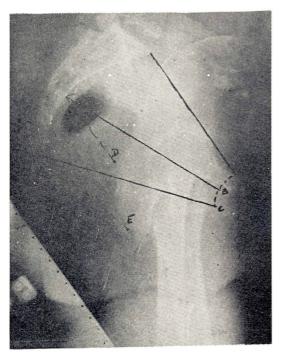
X-ray pelvimetry — lateral projection, showing various antero-posterior diameters. A = inlet true conjugate. B = antero-posterior diameter of mid-pelvis. C = antero-posterior of outlet. D = post-sagittal diameter of mid-pelvis. E = post-sagittal diameter of outlet.
